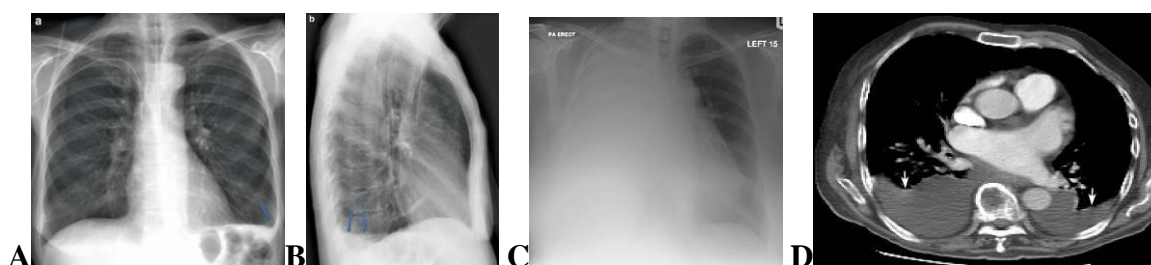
PA (A) and lateral (B) erect projections of the chest demonstrate blunting of left costophrenic angle with a meniscus peripherally on the PA and posteriorly on the lateral (arrows) at limited exudative pleurisy. (C) Radiograph of chest frontal projection, large right pleural effusion. Note the mediastinal shift away from the effusion. (D) Pleural effusion on CT. CT is done in the supine position. Fluid settles in the dependent portion in the back of chest. The white arrows point to bilateral pleural effusions
